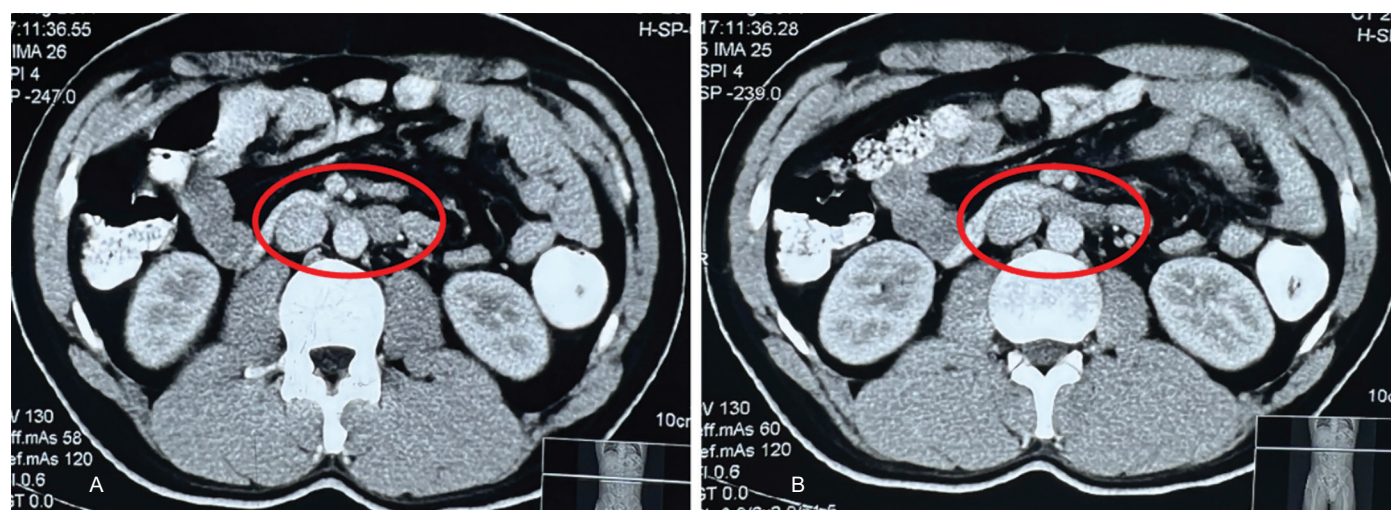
CT Image showing retroperitoneal nodes
